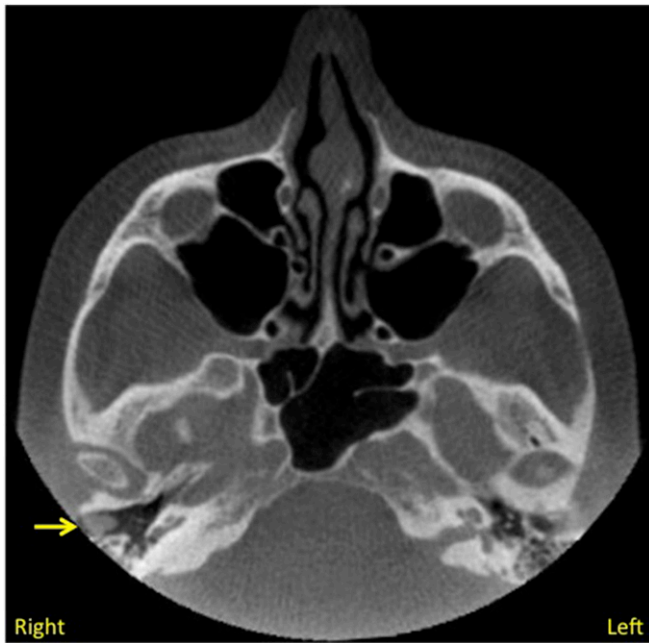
CBCT slice in the axial plane showing foreign body in the right external auditory canal (arrow).
